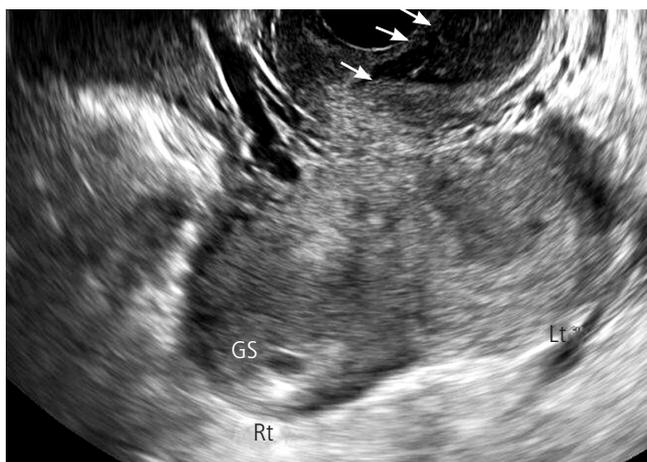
Two-dimensional ultrasonographic image of septate uterus with hemioctobered vagina. The gestational sac (GS) in the right (Rt) uterus and fluid collection in the obstructed left (Lt) vagina (white arrows) are shown.
